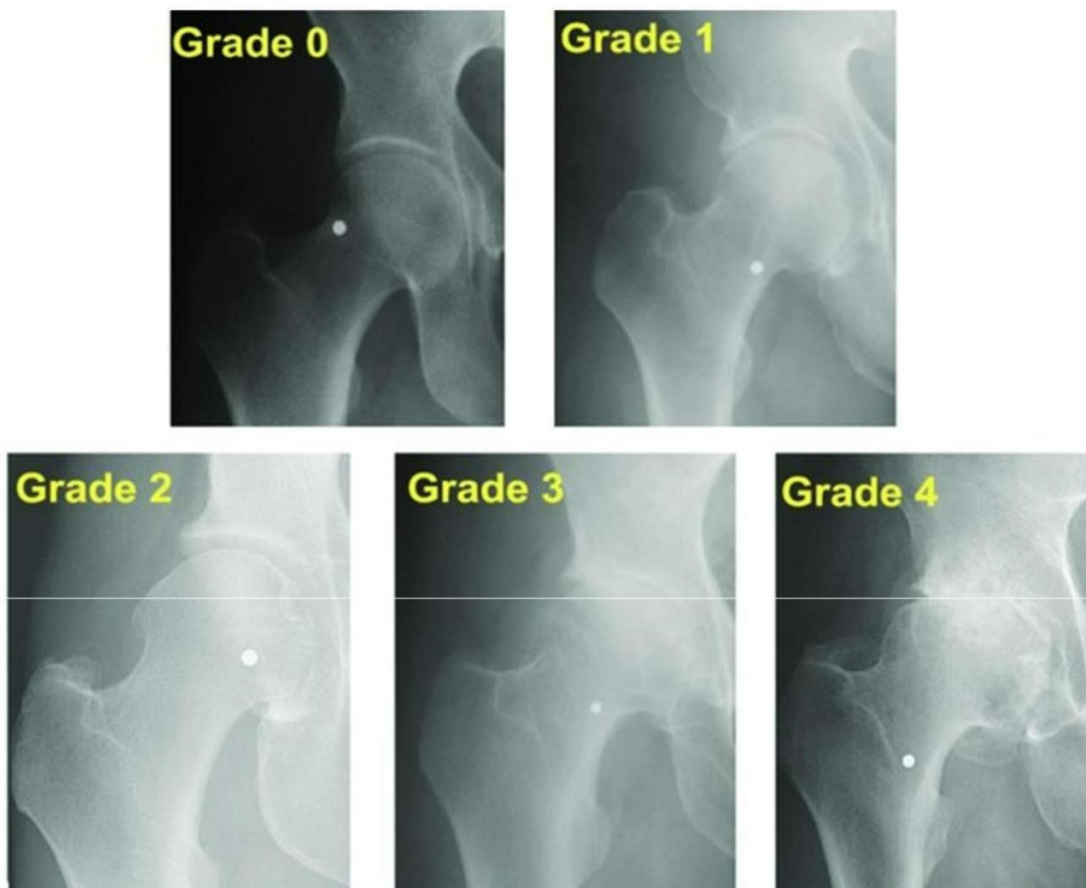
Example plain radiographs showing the Kellgren and Lawrence radiographic hip osteoarthritis severity grading.^{.66}
